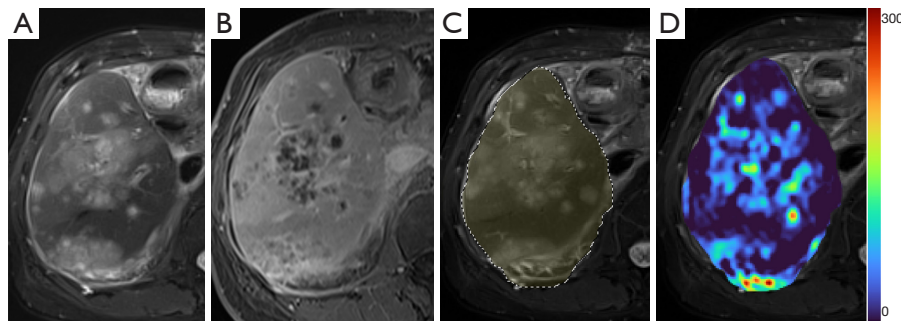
An example of DDVD map with liver region segmented and overlaid on $b=0$ s/mm² DW image. This patient had cholangiocarcinoma with metastasis and was under treatment. DDVD map is computed from $b=0$ and $b=10$ s/mm² images, showing multiple tumor sites with increased DDVD relative to the liver parenchyma and thus suggesting increased blood perfusion for the tumor nodules. (A) T2-weighted anatomical image; (B) gadolinium enhanced T1-weighted image; (C) $b=0$ s/mm² DW image with liver region segmented by a ROI (dashed circle); (D) DDVD map of the liver region is overlaid on $b=0$ s/mm² DW image. DDVD, diffusion-derived vessel density; DW, diffusion weighted; ROI, region-of-interest.
